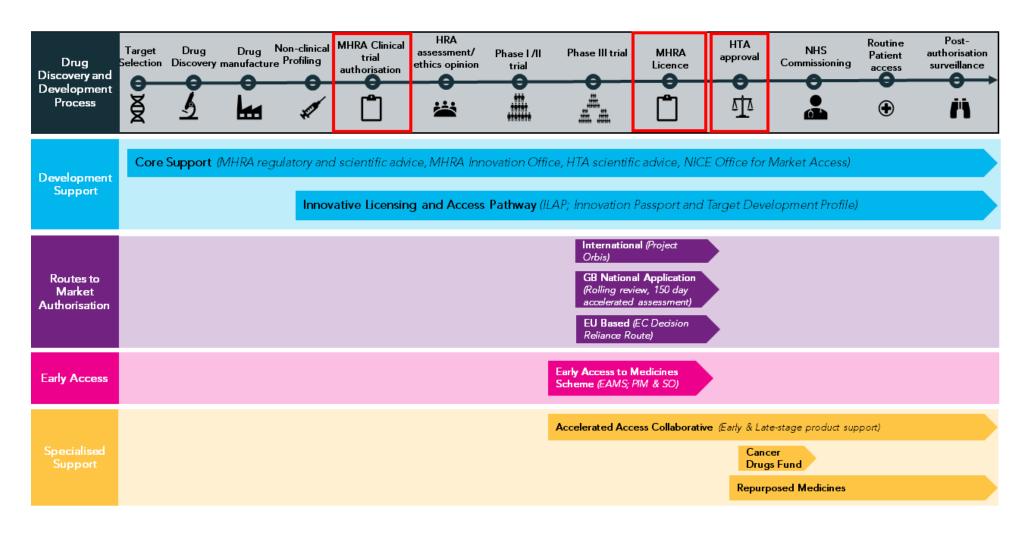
The end-to-end process of oncology drug development, approval and access in Great Britain. The three main approvals milestones are highlighted: initial clinical trial authorisation (CTA) from MHRA, an MHRA marketing licence and HTA (e.g. NICE) approval for prescribing in NHS.
